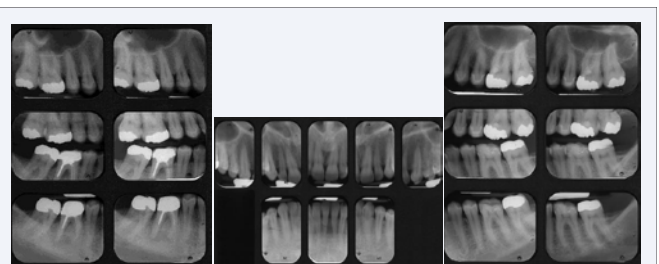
DPost Operative Radiograph Series: Gold Cementation Agent.
